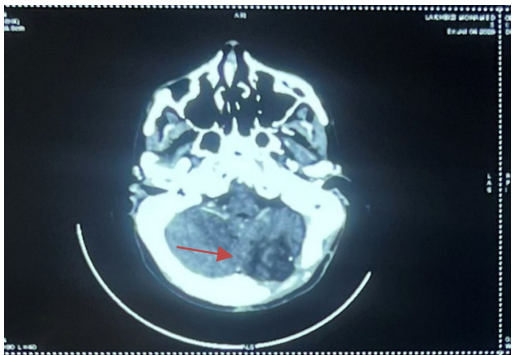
Axial brain CT scan showing a left occipital subdural empyema (arrow) measuring 11 mm in thickness.
